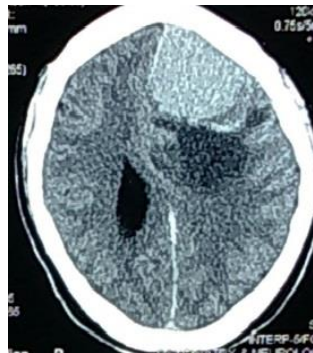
CT brain, axial cut showing Pre-embolized left parasagittal meningioma with marked perilesional edema.
